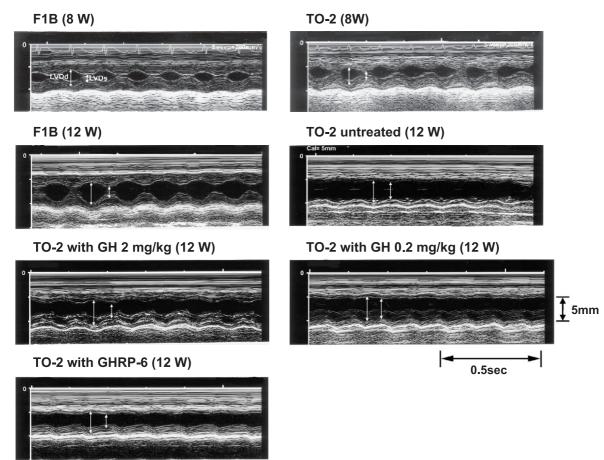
Representative LV M-mode echocardiograms for F1B and TO-2 hamsters at 8 weeks of age, F1B and untreated TO-2 hamsters at 12 weeks of age, and TO-2 hamsters treated with either GH (0.2 or 2 mg/(kg day)) or GHRP-6 at 12 weeks of age.
